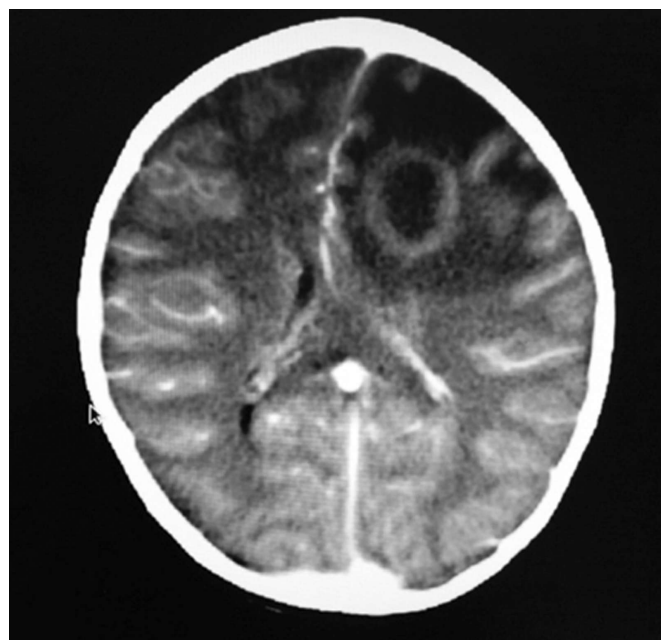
CT brain with contrast showing multi lobulated hypodense lesion in left frontal lobe showing post contrast ring enhancement (arrows) with extensive surrounding edema and mass effect.
